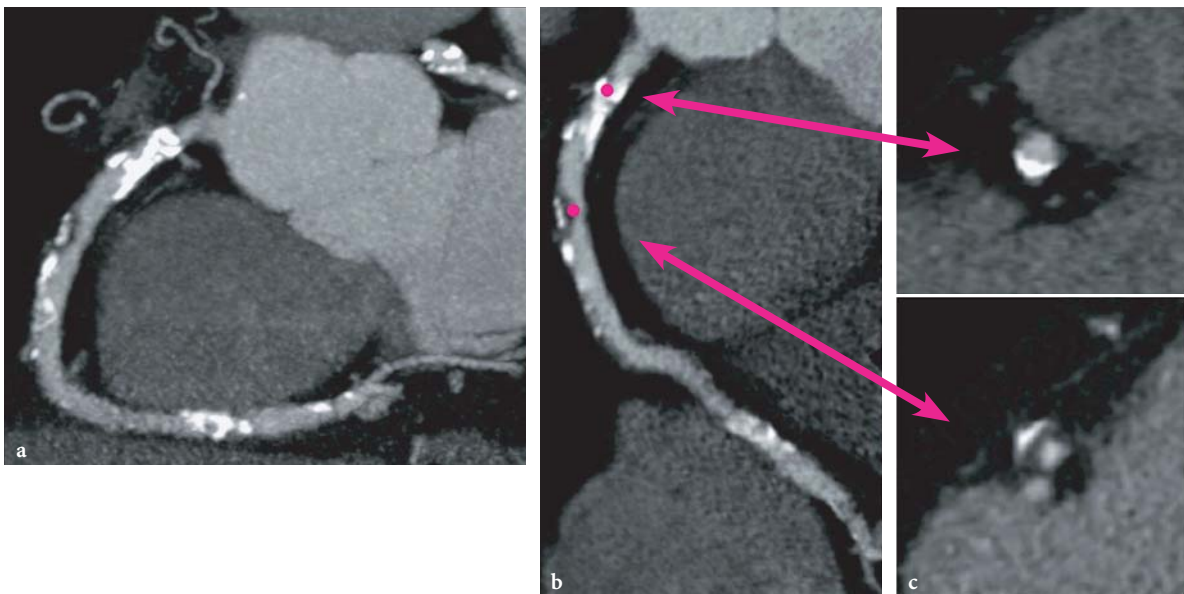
Automated coronary analysis for a patient examination obtained on a 64-slice CT scanner with acquisition of 64×0.6 -mm slices per rotation. The software generates a a thin-slab curved MIP along the RCA and b a curved MPR along the RCA based on the detected center line and c two cross-sections perpendicular to the centerline of the RCA in this patient with severe 3-vessel disease. The *pink dots* mark the positions of the cross-sectional images. (Case courtesy of Mayo Clinic Rochester, Minnesota, USA)
